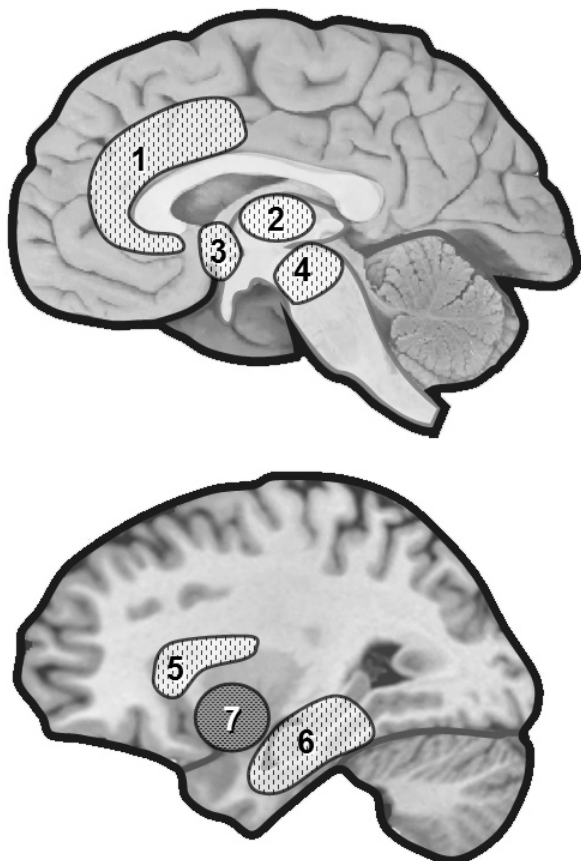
Regional cerebral metabolism during NREM sleep in idiopathic insomnia. Nofzinger et al. found increased regional metabolism (^{18}F FDG PET) from waking to NREM sleep in patients with idiopathic insomnia.⁷ Smith et al. found reduced regional cerebral blood flow (SPECT) in the basal ganglia in insomniacs.¹¹ 1 = anterior cingulate, 2 = thalamus, 3 = hypothalamus, 4 = ascending reticular activating system, 5 = insula, 6 = medial temporal, 7 = basal ganglia.
